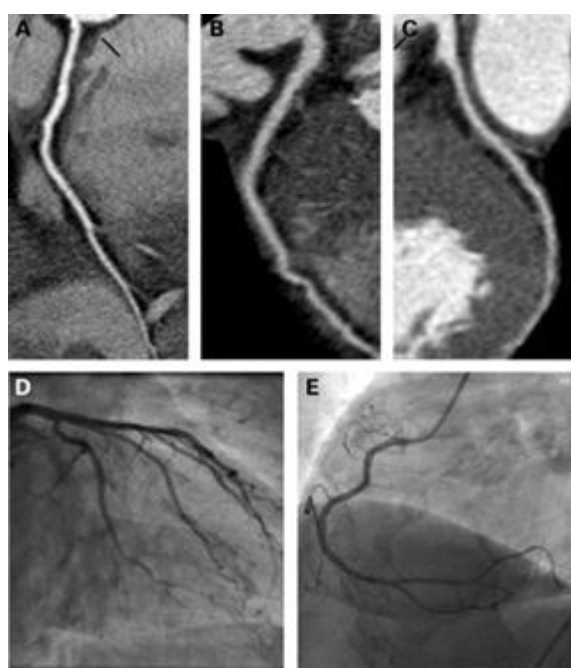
A, B, C, D, E Curved multi planar reconstruction images demonstrate diagnostic image quality of the right coronary artery (A); left anterior descending coronary artery (B) and left circumflex artery (C). No plaque, stenoses were present in CTA confirmed by CCA (D&E)
